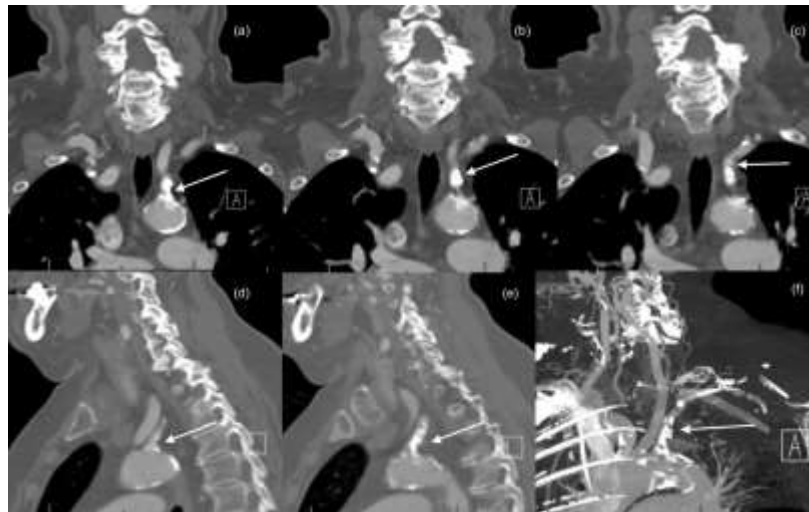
Sequential Coronal (a, b, c), sagittal (c, d) and Maximum Intensity Projection (e) reformatted images of CTA in a 79-year-old female showing severe atherosclerotic narrowing in the left subclavian artery (White arrow).
